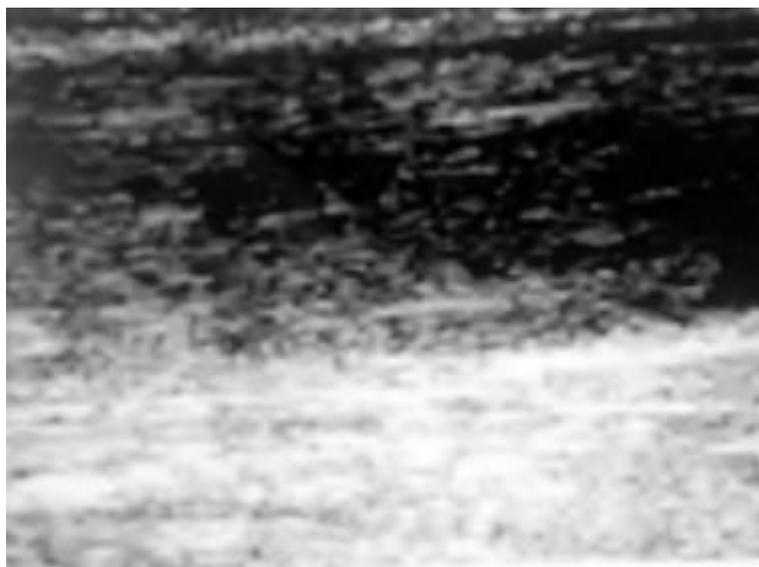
Longitudinal ultrasonographic scan of right Achilles tendonitis.
